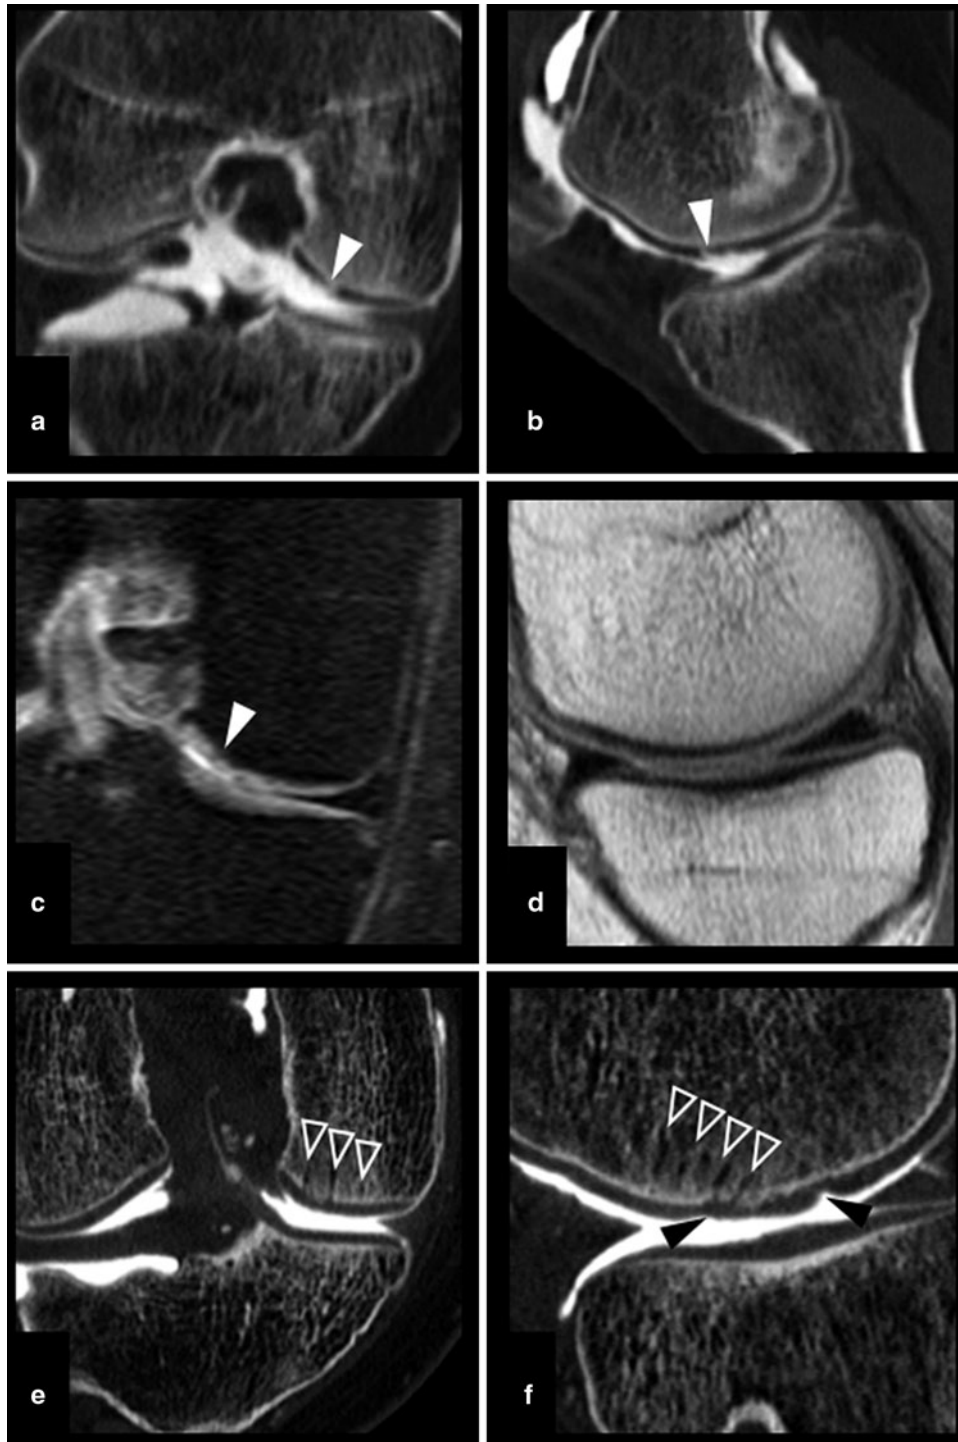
(a–f) Thirty-five-year-old woman with a history of knee trauma. (a) Coronal and (b) sagittal reformats of computed tomographic (CT) arthrography show a grade 4 cartilage lesion of the medial femoral condyle. (c) Coronal DP-weighted fat-suppressed image and (d) sagittal DP-weighted magnetic resonance (MR) image
